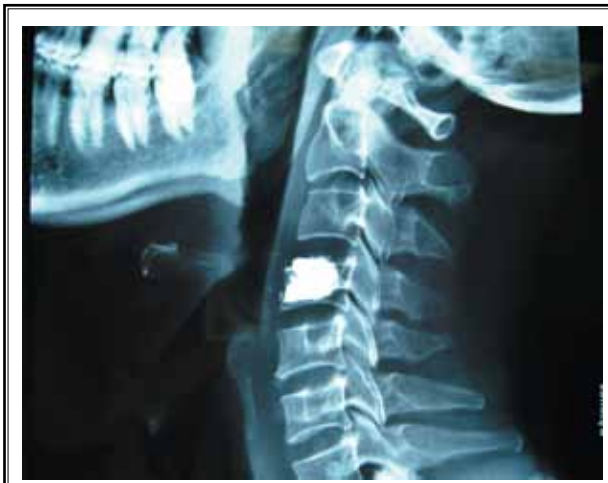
Postoperative lateral radiograph revealed adequate and homogeneous cement distribution.
